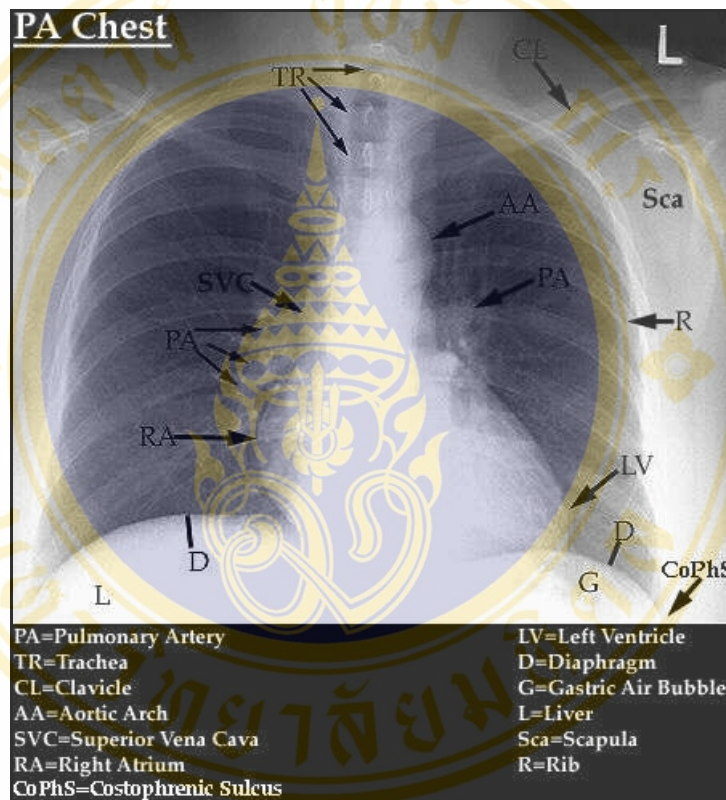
Normal PA chest radiography
